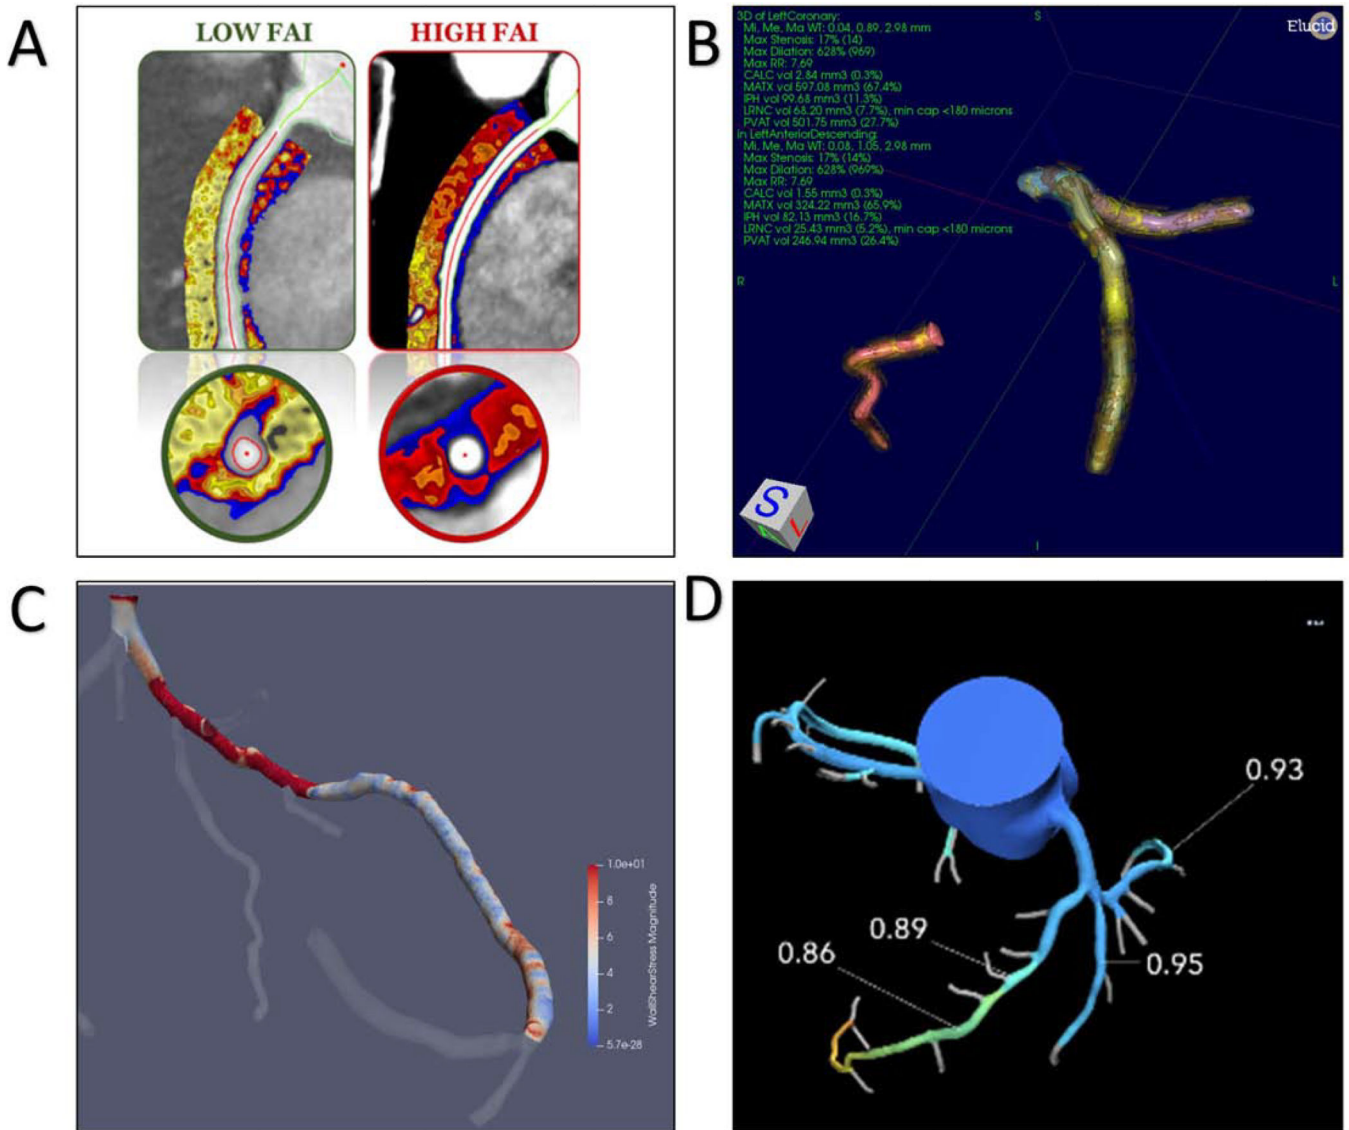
Emerging technologies derived from Coronary Computed Tomography Angiography. (A) Two patients with high and low perivascular fat attenuation index (FAI) identified on coronary computed tomography angiography (CCTA) are shown. (B) Plaque quantification and characterization from CCTA using vasuCAP (Elucid Bioimaging) is shown in a 3-dimensional view of the left and right coronary arteries. (C) Example of a wall shear stress (WSS) profile superimposed on a coronary artery tree from CCTA. Reproduced with permission from Samady et al (96). (D) FFR_{CT} calculations (HeartFlow) are superimposed on a coronary artery tree extracted from CCTA.
